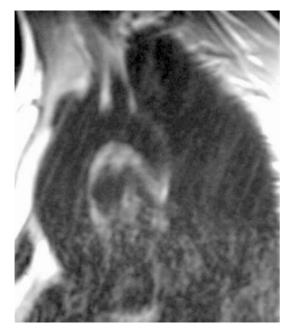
Parasagittal T1-weighted MRI showing proximal ascending aortic ectasia
